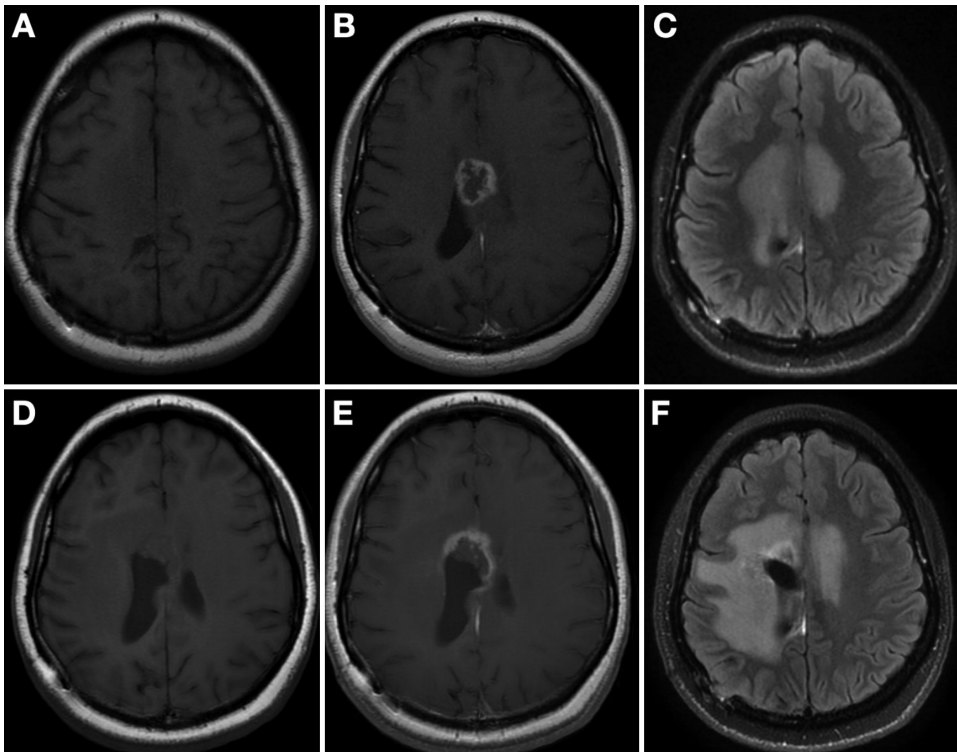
Axial T1-weighted MRI without contrast, 6 months postresection, before stereotactic radiosurgery (A) compared to T1-weighted MRI with contrast showing slightly increased enhancement in the inferior margin of the resection cavity as well as the corpus callosum (B). These findings were also visualized on the T2-FLAIR sequence (C) before the patient underwent stereotactic radiosurgery.
